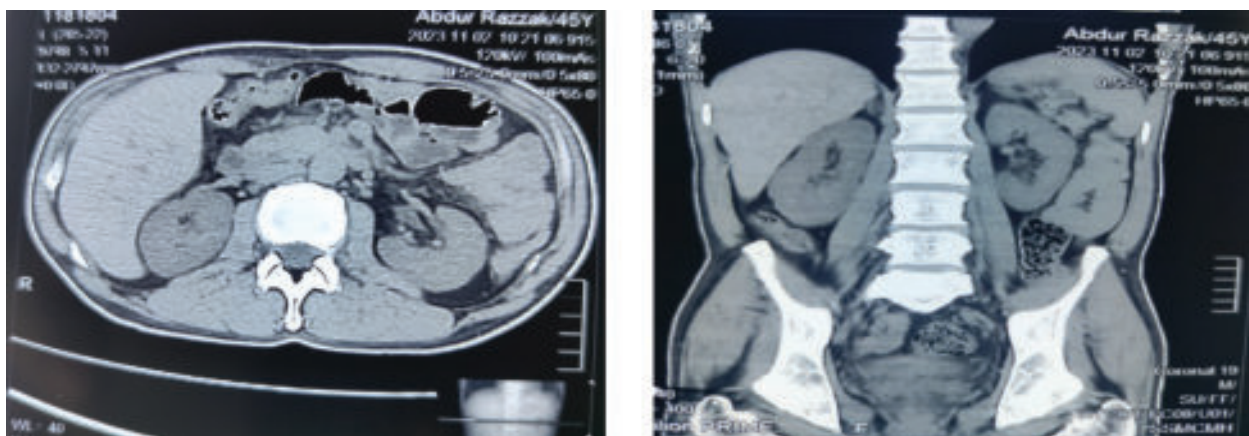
CT features consistent with mild hepatomegaly tiny right renal calculi but no adreanal adenoma/ hyperplasia
